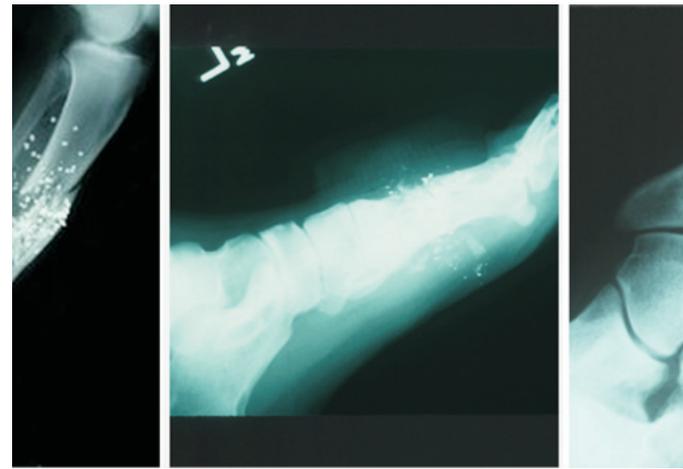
Radiographic imaging showing the effect of high velocity projectiles on bone.
